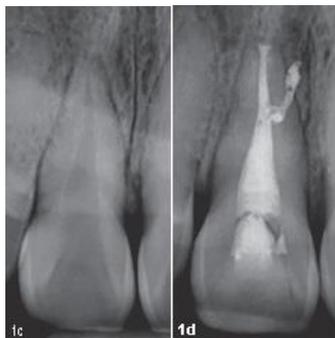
c. radiography of tooth 11 , before treatment . 5.1.d endodontic treatment of tooth 11 .(24)
